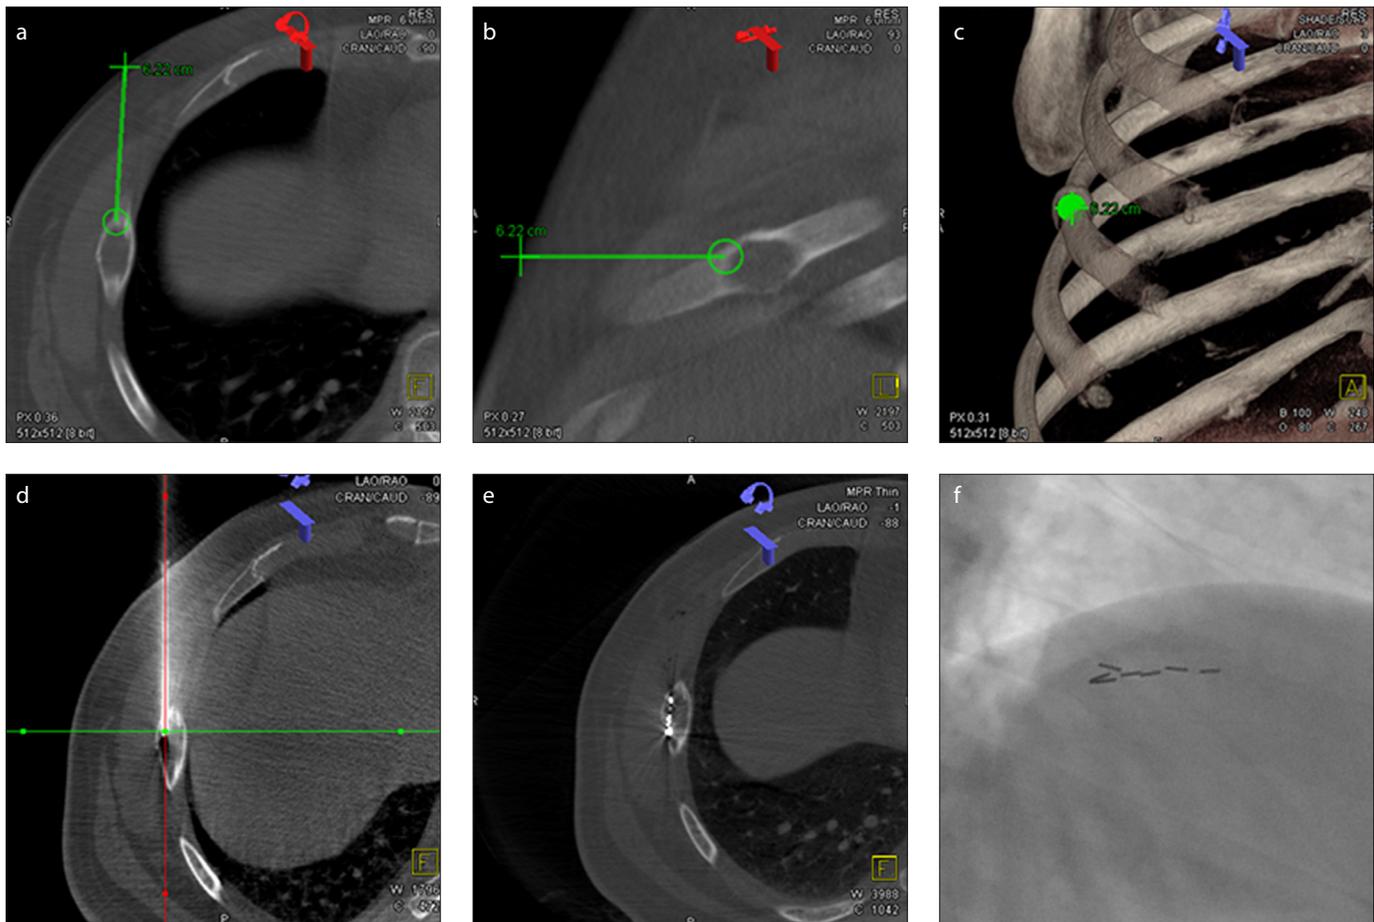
a–f. Axial (a) and coronal (b) DynaCT images show rib transfer in a 67-year-old male prostate cancer patient. According to the TPS plan, pre-puncture path was selected and implantation of ^{125}I seeds was completed based on the selected path (c–e). Digital radiography (f) image confirms that the ^{125}I seeds have been successfully placed at the specified location. After implantation of ^{125}I seeds, the patient's VAS pain score was reduced from 7 points to 4 points, and the pain was significantly relieved.
